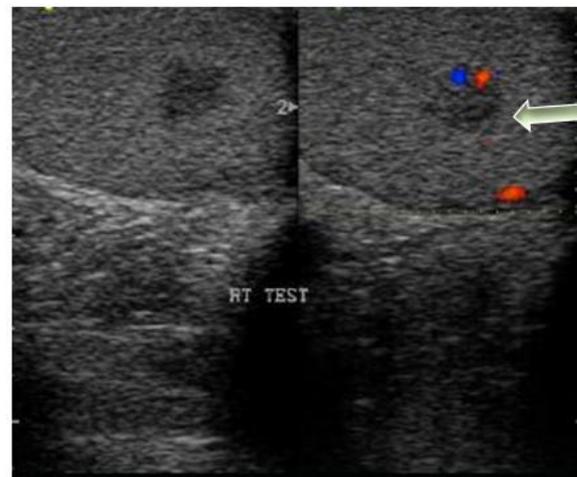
b: Colour Doppler shows increase blood flow (Focal Orchitis – Colour Doppler Image)
